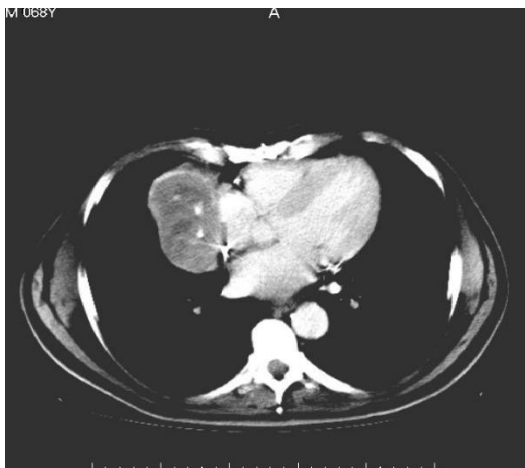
A computed tomography image of the thorax showing the saccular aneurysmal vascular structure
